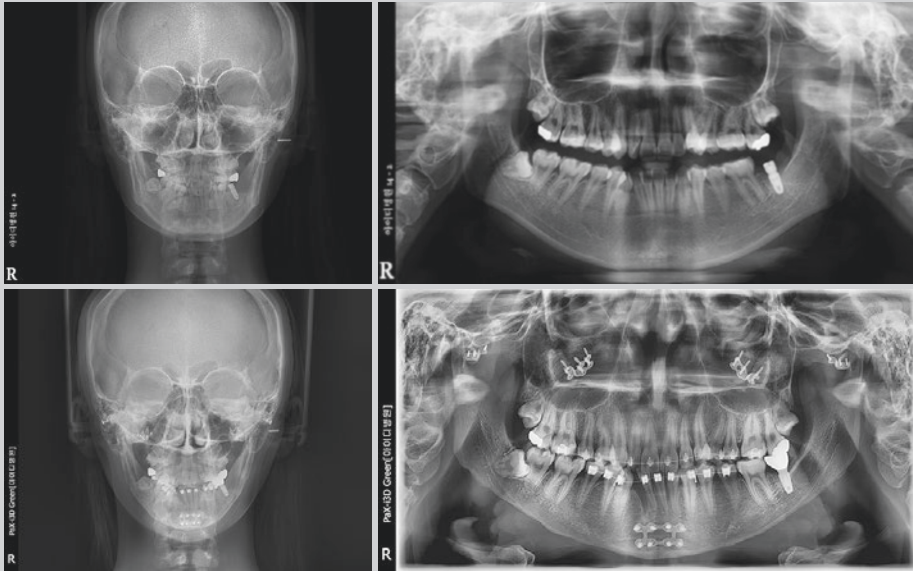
(Case 1) Preoperative radiograph (above). Follow-up radiograph 6 months after surgery (below)
